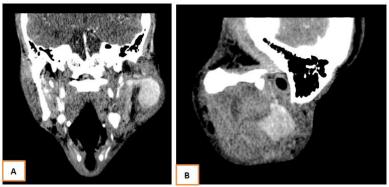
Cervical CT with contrast medium, coronal (A) and sagittal (B) reconstructions: Enhanced oval formation, in contact with the occipital branch of the left external carotid artery
